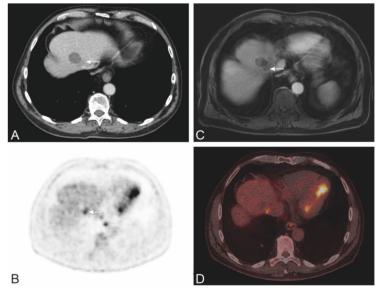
Recurrent disease after liver MWA. Images of contrast enhanced CT (A), PET (B), contrast enhanced MRI (C) and PET/CT (D) are depicted.
